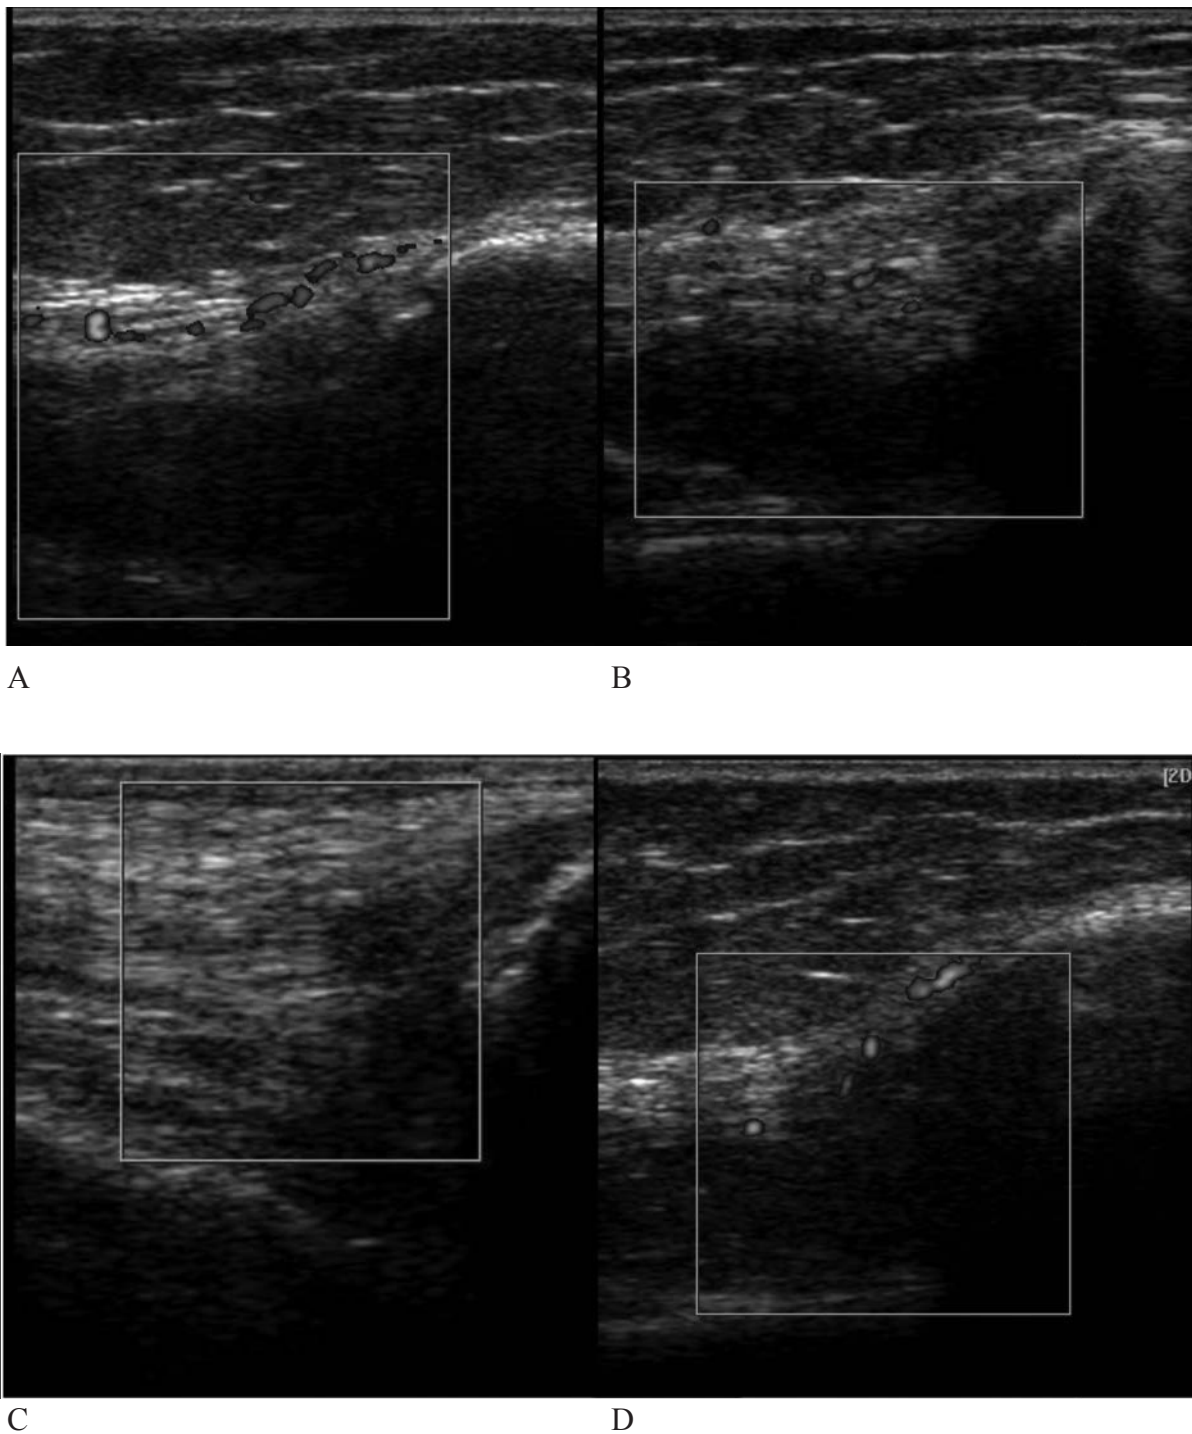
Power Doppler ultrasonography of knee of a patient with RA showing : (A) Doppler activity of grade 3 before intra_articular MTX injection (WEEK 0), (B) Doppler activity (grade 2/3) 5 weeks after intra_articular MTX injection (WEEK 5), (C) No Doppler activity (grade 0/3) 3 months after intra_articular MTX injection (WEEK 20) , (D) Doppler activity (grade 2/3) 6 months after intra_articular MTX injection (WEEK 32)
